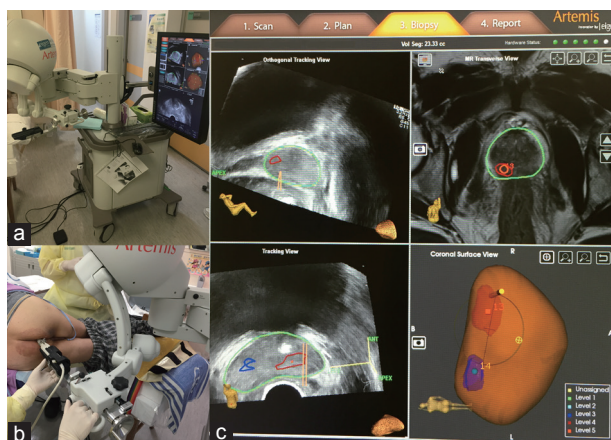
(a) The Artemis elastic fusion platform. (b) An example shows a PIRADS 3 lesion at the left peripheral base and a PIRADS 4 lesion at the right peripheral base of the prostate in a fusion biopsy patient. (c) During the biopsy procedure, the ultrasound probe is docked to the robot-like mechanical arm with encoders (angle-sensing devices) within each joint for tracking of probe position. After fusion of MR images with real-time TRUS images, target lesions will show up as areas of interests in the three-dimensional prostate model. MR: magnetic resonance imaging; TRUS: transrectal ultrasound.
